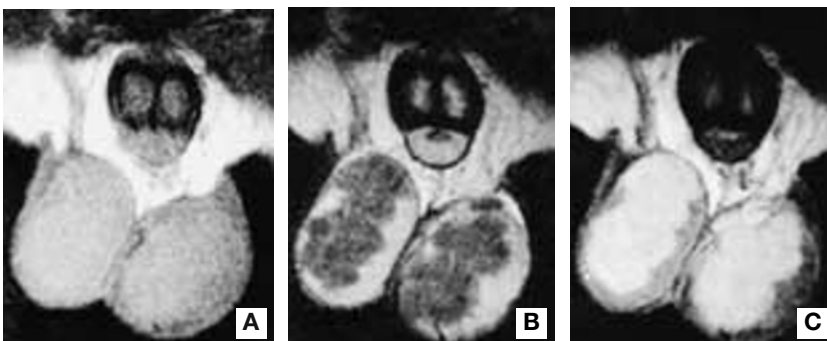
Magnetic resonance shows: A) unenhanced coronal T1-weighted spin-echo with no evidence of the testicular lesions; B) in T2-weighted images lesions are marked hypointense compared to the normal testis; C) in enhanced T1-weighted images after paramagnetic contrast media infusion lesions show marked and diffused hyperintensity.
